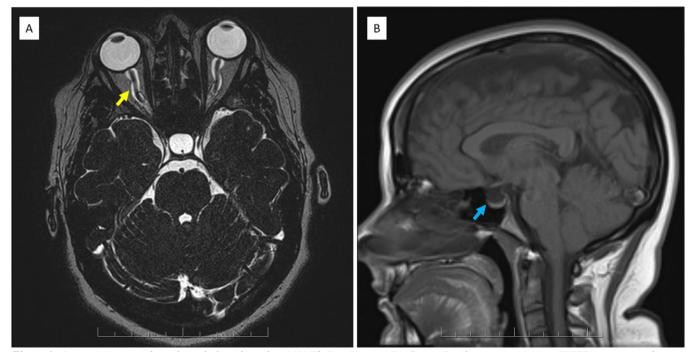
Image A is an axial cut through the orbits of an MRI T2 Fast Imaging Employing Steady-state Acquisition (FIESTA) sequence showing bilateral optic nerve sheath tortuosity and dilatation (yellow arrow). Image B is a sagittal cut through the corpus callosum of a non-enhanced MRI T1 sequence demonstrating an empty sella (blue arrow).
